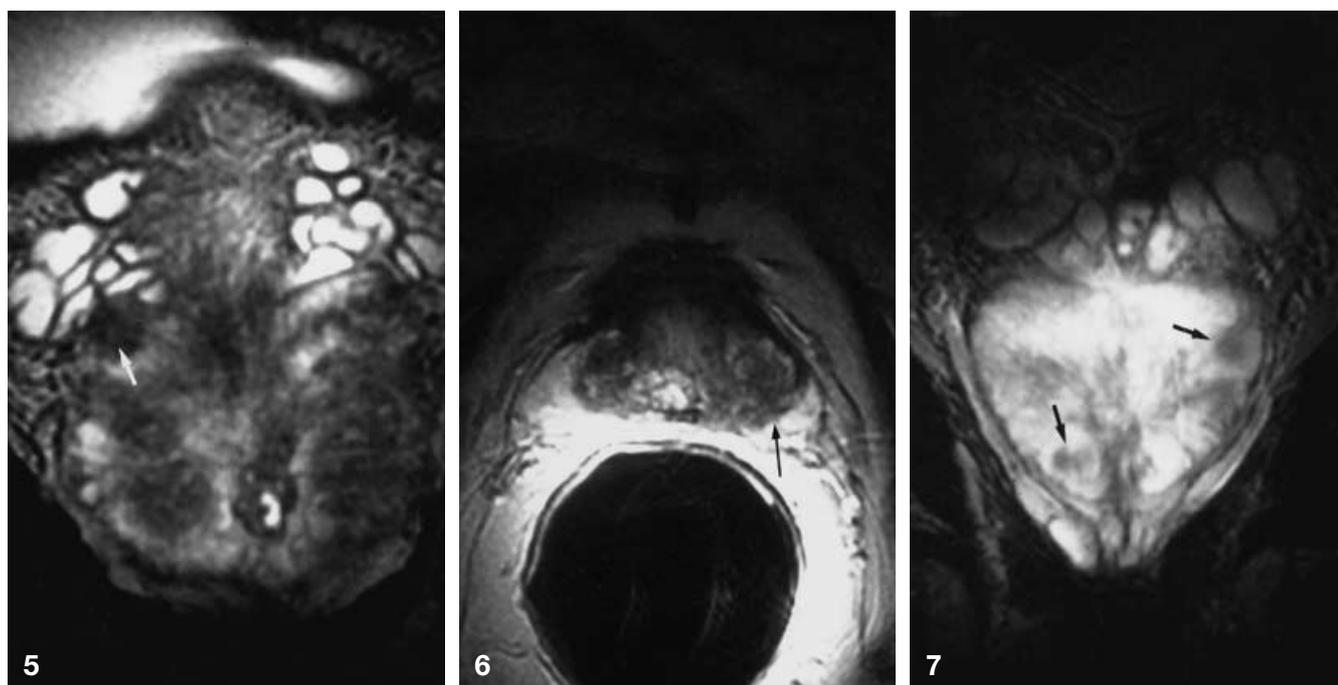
Prostatic hyperplasia. Coronal T2-weighted image in a 69-year-old patient with a PSA 6 ng/ml, showing a nodular low-signal-intensity lesion (*arrow*) in the right base of the prostate. Malignancy was suspected by endorectal MR imaging and biopsy showed hyperplasia
